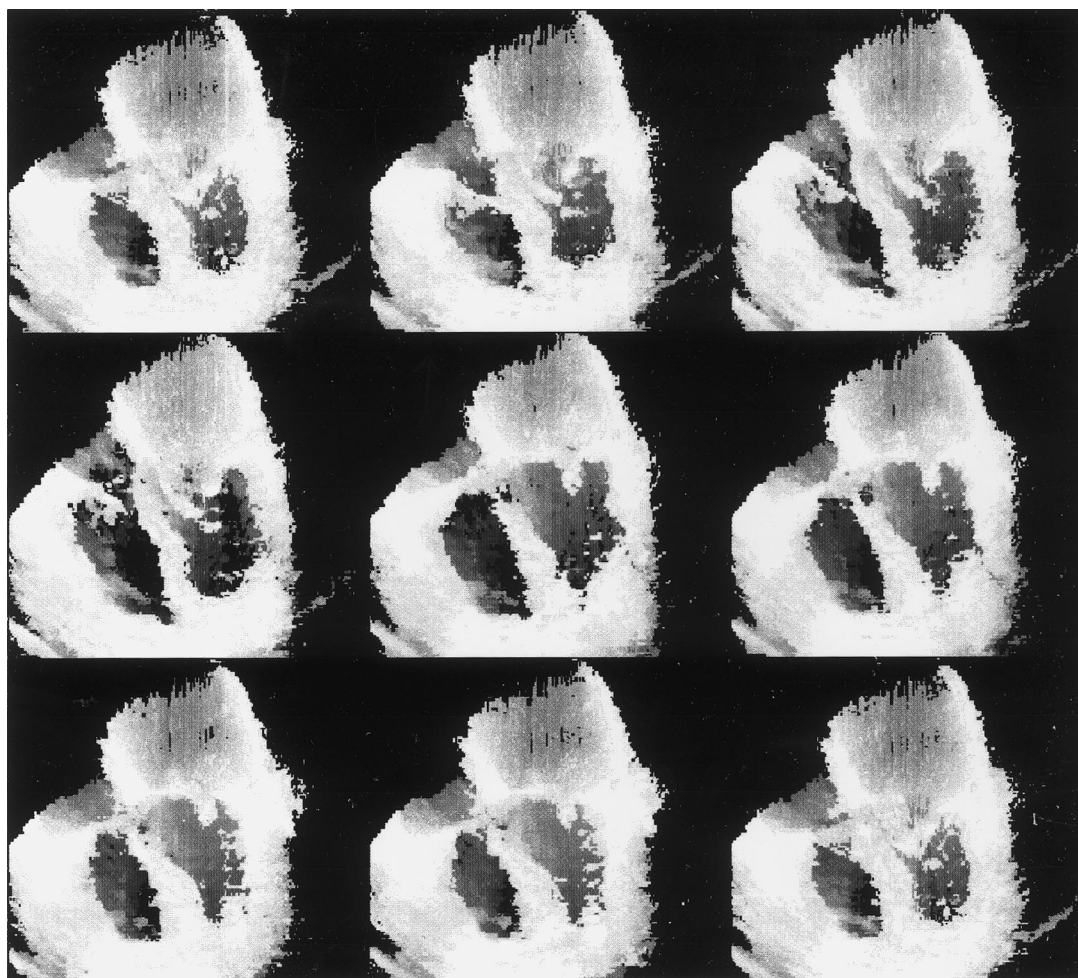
Contiguous image frames extracted from the 4D echocardiography reconstructed by the developed system. The activity of the mitral valve can easily be observed in the dynamic 4D echocardiography.
